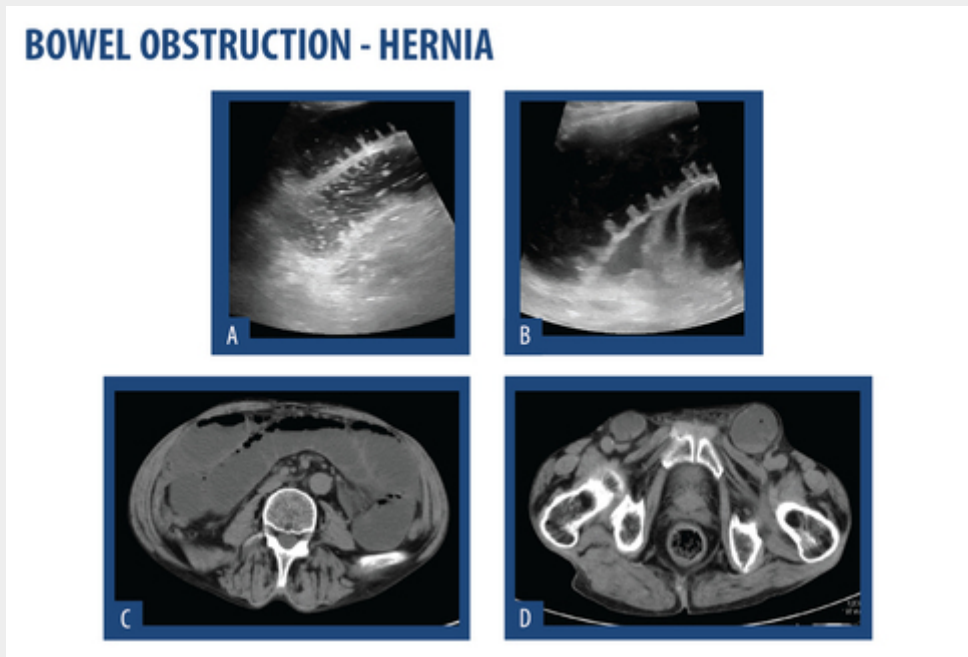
53 year-old that present with generalized abdominal pain, drowsiness and altered bowel habits. He had a history of alcoholism. On US (A,B) there was marked bowel distention, involving the small and large bowel. The loops were filled with fluid. No cause of obstruction was identified. He underwent CT (C,D) which revealed two internal hernias, filled with bowel (notice the fluid within the bowel loop), causing the obstruction.
